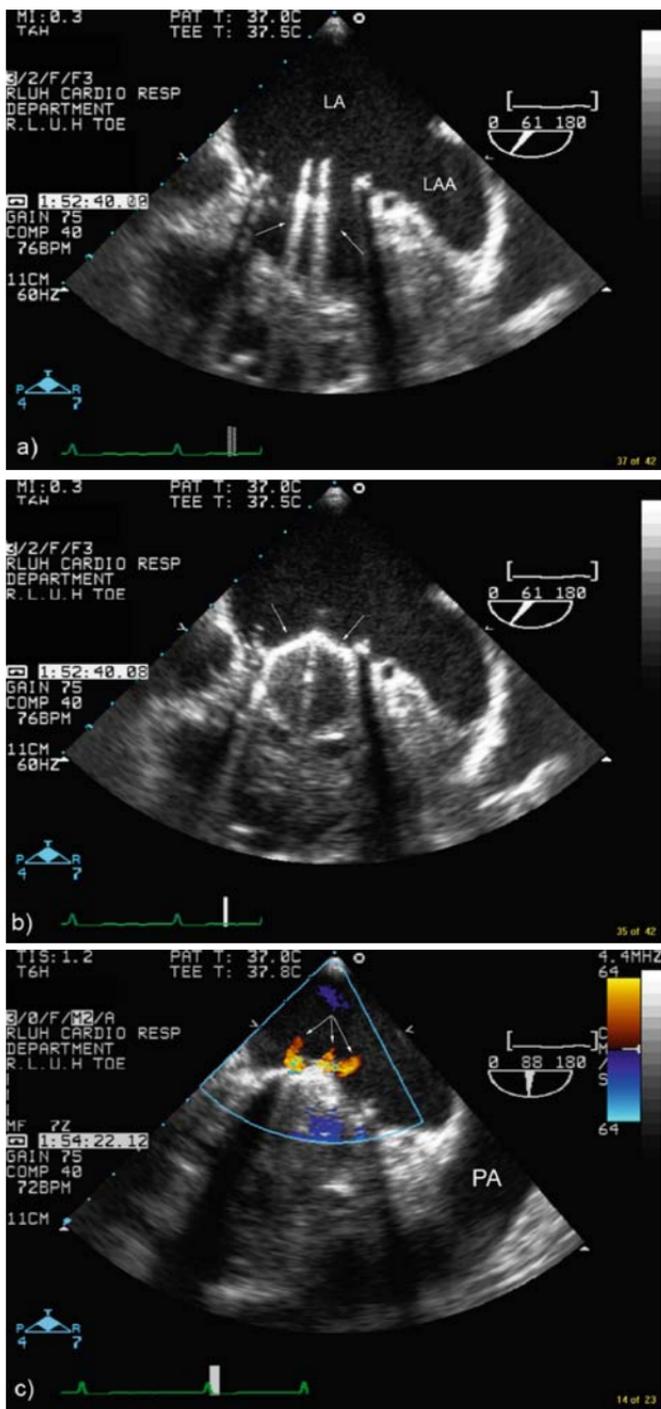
Transesophageal echocardiography (TEE) imaging of a normally functioning St. Jude valve in mitral position. a Diastolic frame showing
